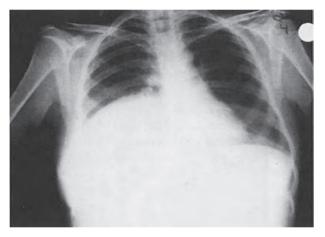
Posteroanterior chest radiograph outlining a large liver with marked elevation of the diaphragm caused by a hydatid cyst of the right lobe.
